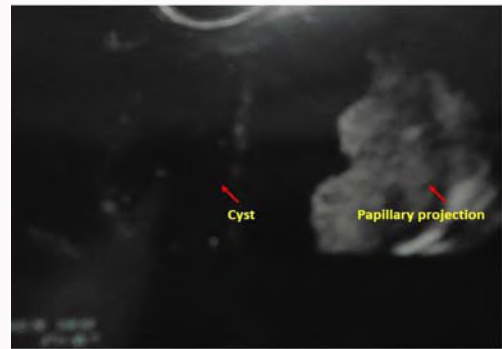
Trans-rectal ultrasonography reveals a cystic lesion in the prostate with left lateral wall of the cyst showing solid papillary projections.
